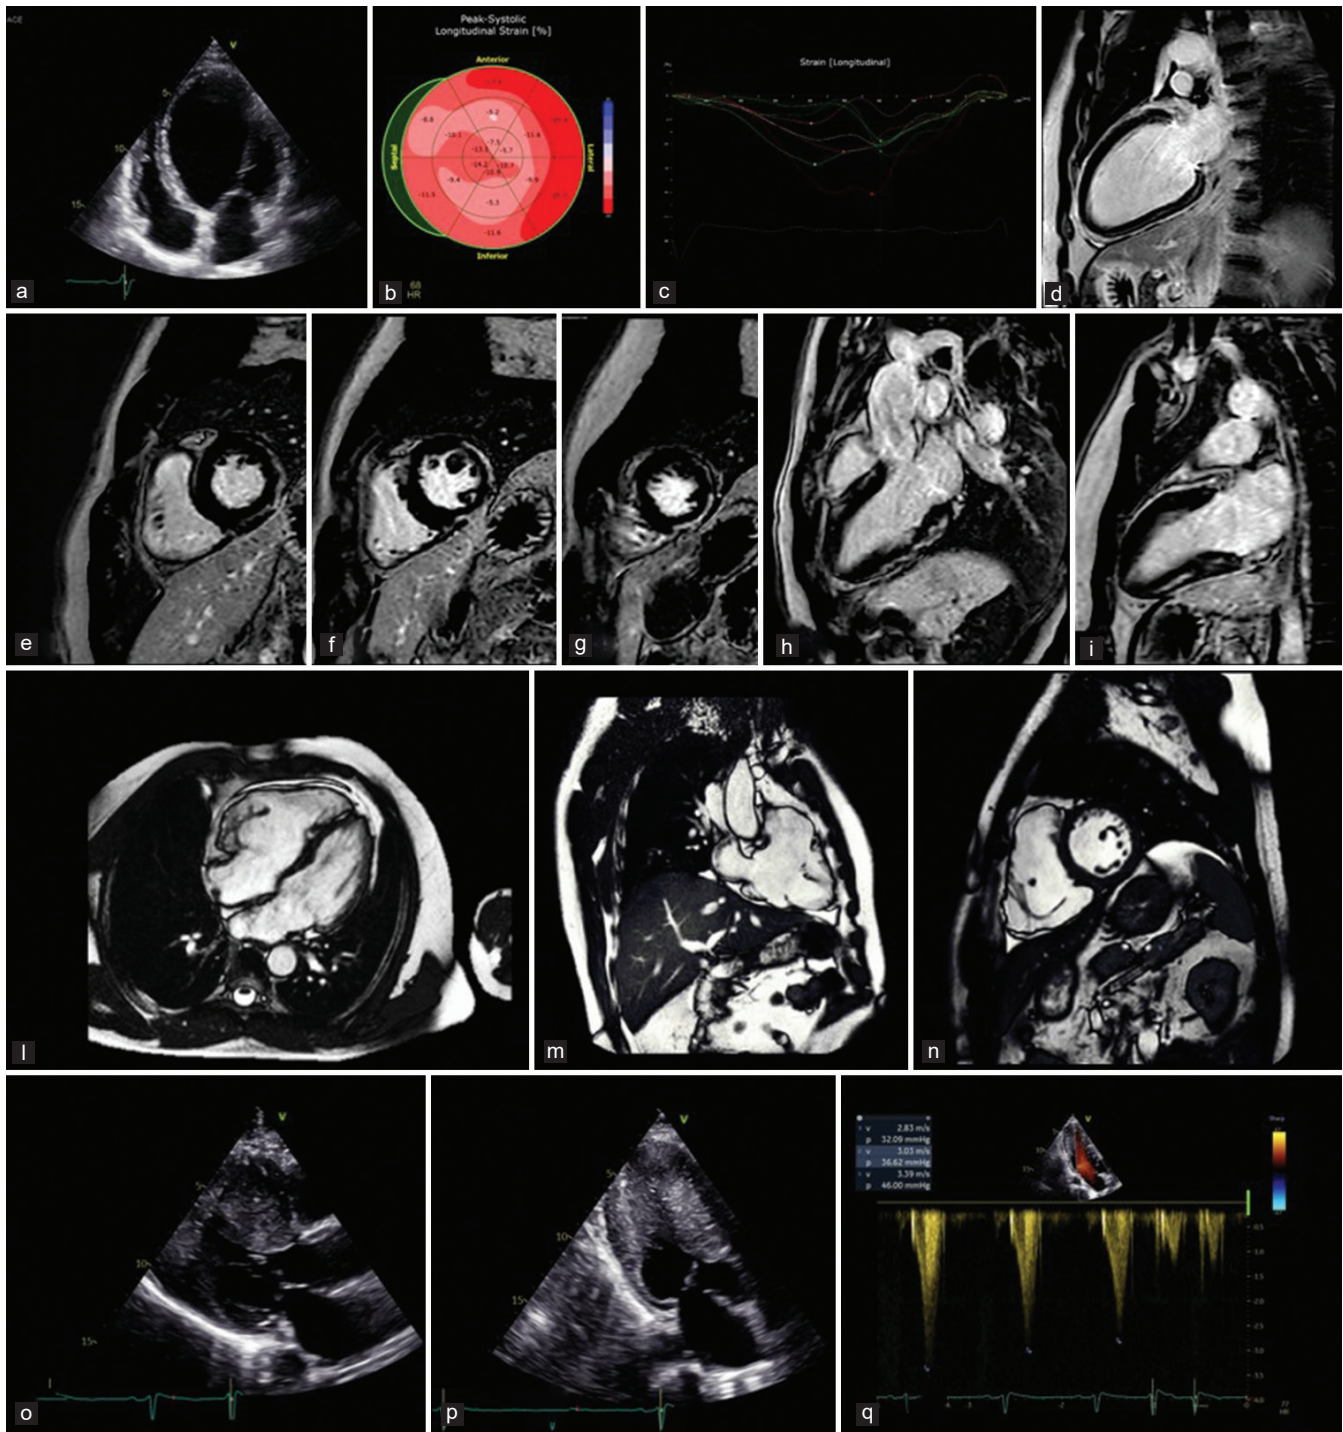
Sudden cardiac death risk stratification in the setting of cardiomyopathies, first section. (a-d) Case of dilated cardiomyopathy in a patient with a pathogenic mutation in the FLNC gene; (a) transthoracic echocardiography, apical four-chamber view: dilatation of the left ventricle with severe systolic dysfunction; (b) reduced global longitudinal strain; (c) increased mechanical dispersion; (d) cardiac magnetic resonance, postcontrast imaging, showing presence of late gadolinium enhancement at the level of the inferior wall. (e-i) Case of non-dilated left ventricular cardiomyopathy with preserved left ventricular systolic function in a patient with a pathogenic mutation in DSP gene; cardiac magnetic resonance, postcontrast imaging, shows the presence of extensive late gadolinium enhancement in the inferior, posterior, and lateral walls. (j-n) Case of arrhythmogenic right ventricular cardiomyopathy in a patient with a pathogenic mutation in the PKP2 gene; cardiac magnetic resonance, cine steady state free precession imaging, showing dilatation of the right ventricle with severe systolic dysfunction, along with the presence of large aneurysms in the sub-tricuspidal region and the right ventricular outflow tract. (o-q) Case of obstructive hypertrophic cardiomyopathy; (o-p) transthoracic echocardiography, showing the presence of severe hypertrophy of the interventricular septum and left ventricular outflow tract obstruction due to systolic anterior motion of the mitral valve; (q) transthoracic echocardiography, continuous wave spectral Doppler: evidence of significant left ventricular outflow tract peak systolic gradient.
